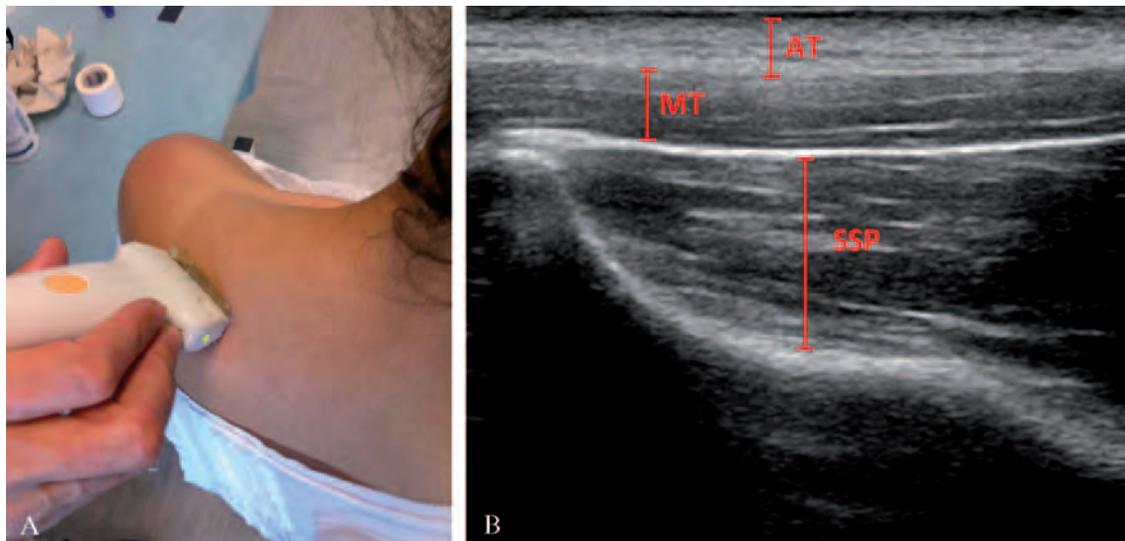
A) Position of trasducer for imaging of supraspinatus muscle thickness. B) Respective ultrasound image. (AT= Adipose tissue, MT = Middle trapezius, SSP = Supraspinatus).
